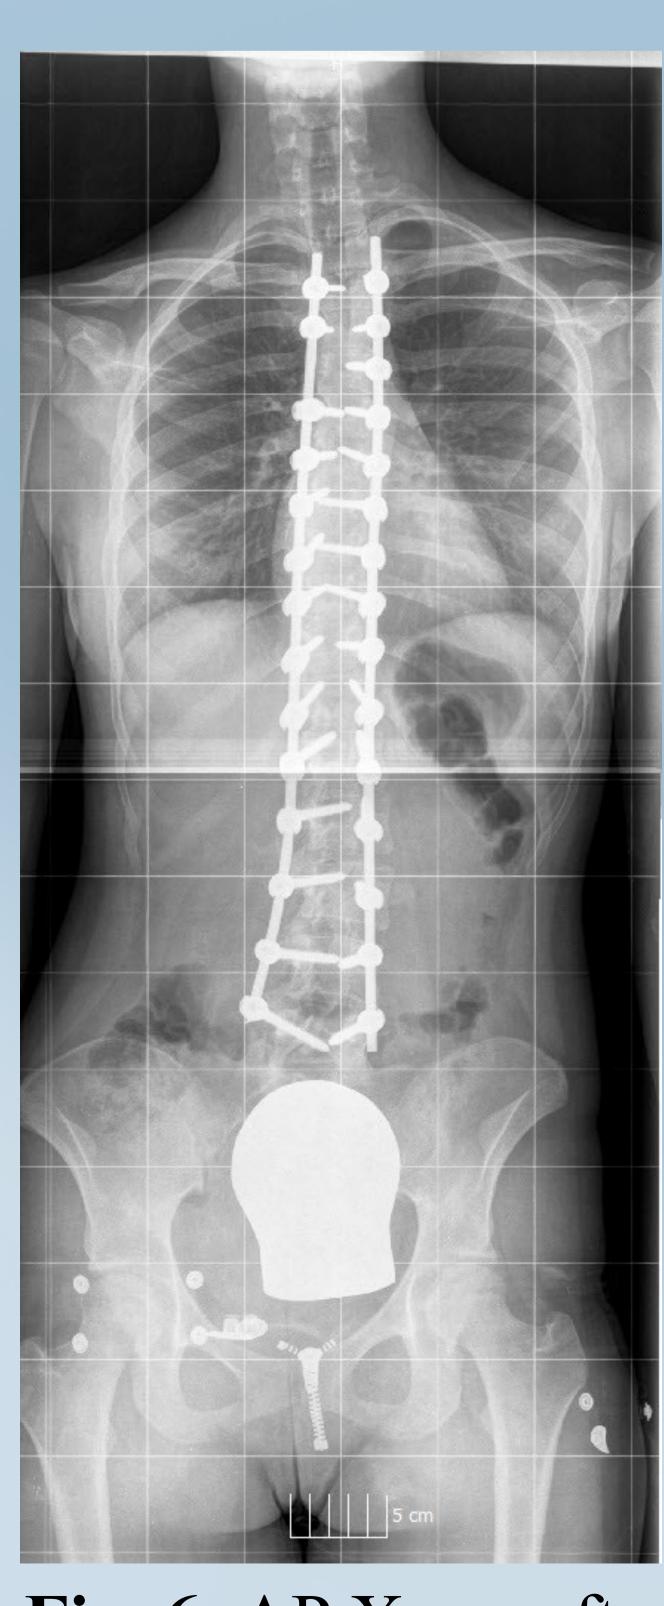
AP X-ray after surgical reconstruction
